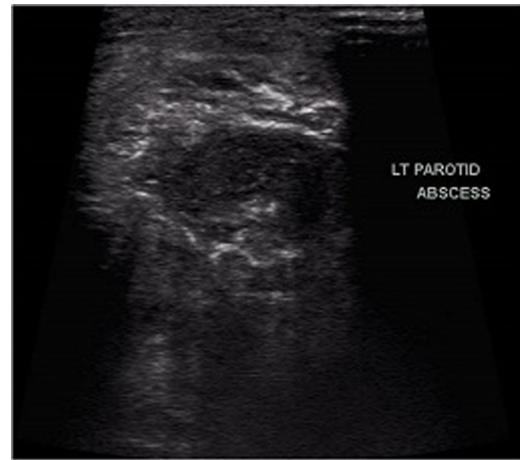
Ultrasound of parotid region on left side showing ill defined heterogeneous collection with multiple thick septations suggestive of abscess and overlying parotid parenchyma appears oedematous.
